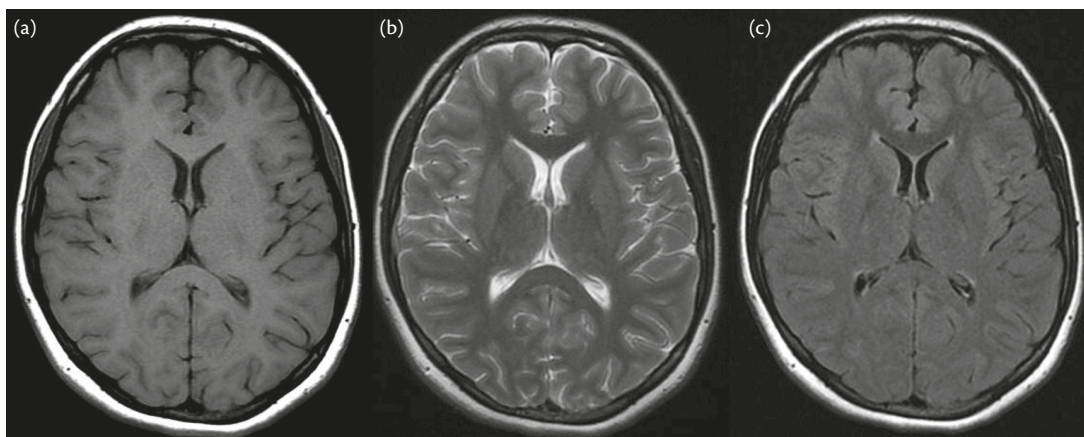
Appearances of the brain on routine MRI sequences. (A) On T₁-weighted image grey matter is darker ('greyer') than white matter. (B) On T₂-weighted image the white matter is darker than grey matter and fluid is hyperintense. (C) T₂-FLAIR show similar contrast between the grey and white matter as T₂-weighted images but the signal from CSF is nulled.
